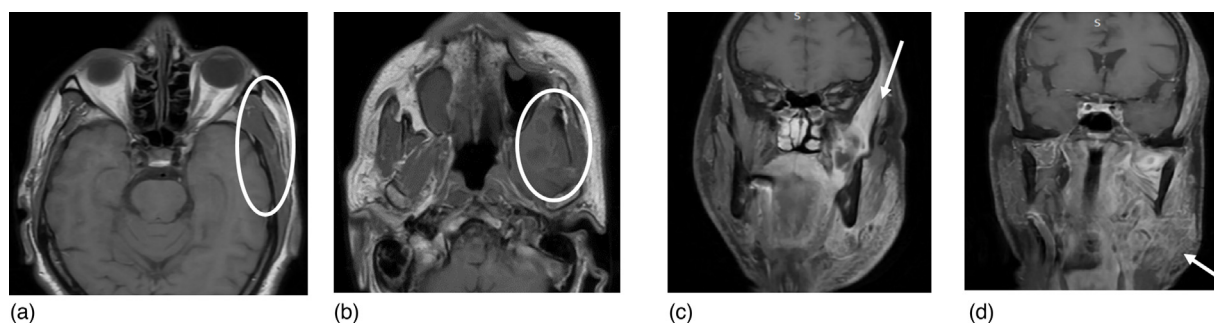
MRI images of the abscess with oedema. (a and b) Axial sections. abscess is highlighted with the white circle. (c and d) Coronal section. The abscess is highlighted with the white arrow.
